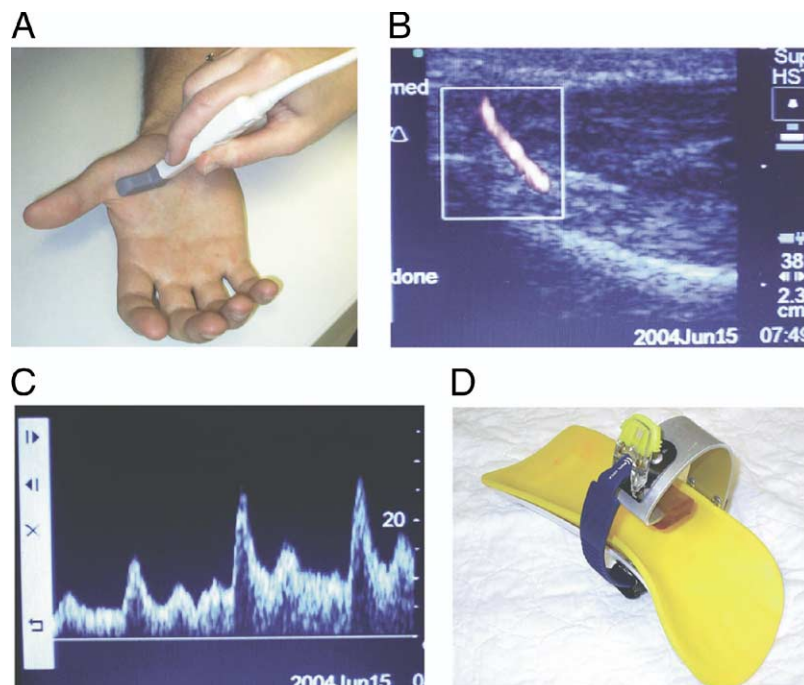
(A and B) Visualizing the principal artery of the thumb (PAT) with color Doppler. (C) Pulsed-wave Doppler of the PAT as the clamp is removed from the radial artery. (D) Clamping device used to occlude the radial artery.
